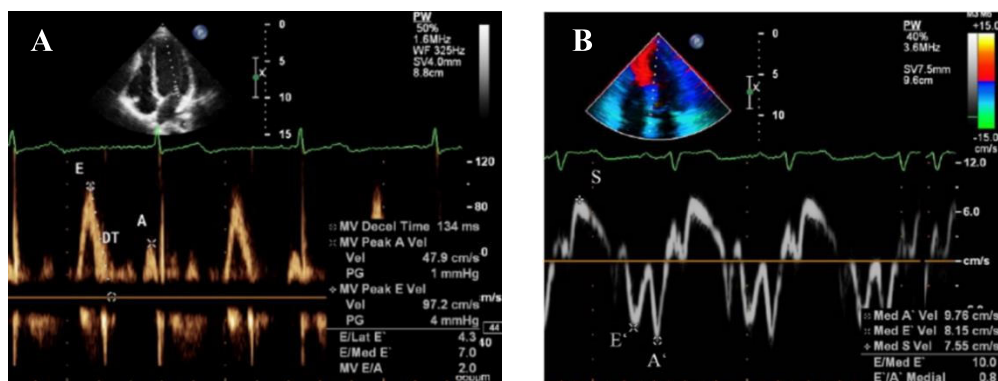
Doppler Echocardiography. (A) Pulsed wave Doppler of mitral filling. E wave: early diastolic filling; A wave: late diastolic filling; DT: deceleration time of the E wave (early mitral filling). (B) Pulsed tissue Doppler of the medial mitral annulus. S wave: systolic velocity above the baseline as a result of the annular movement toward the apex; E'm: early diastolic velocity below the baseline due to annular movement away from the apex; A'm: late diastolic velocity, at the time of atrial contraction (Kinova & Goudev, 2012)
